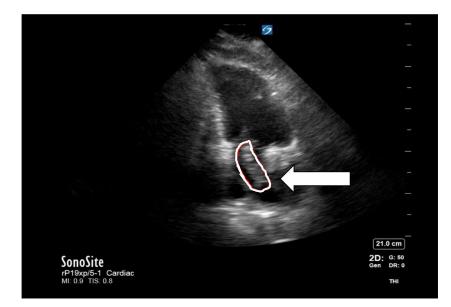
Point-of-care ultrasound showing both clot extension and an enlarged right ventricle suggestive of acute pulmonary embolism.
